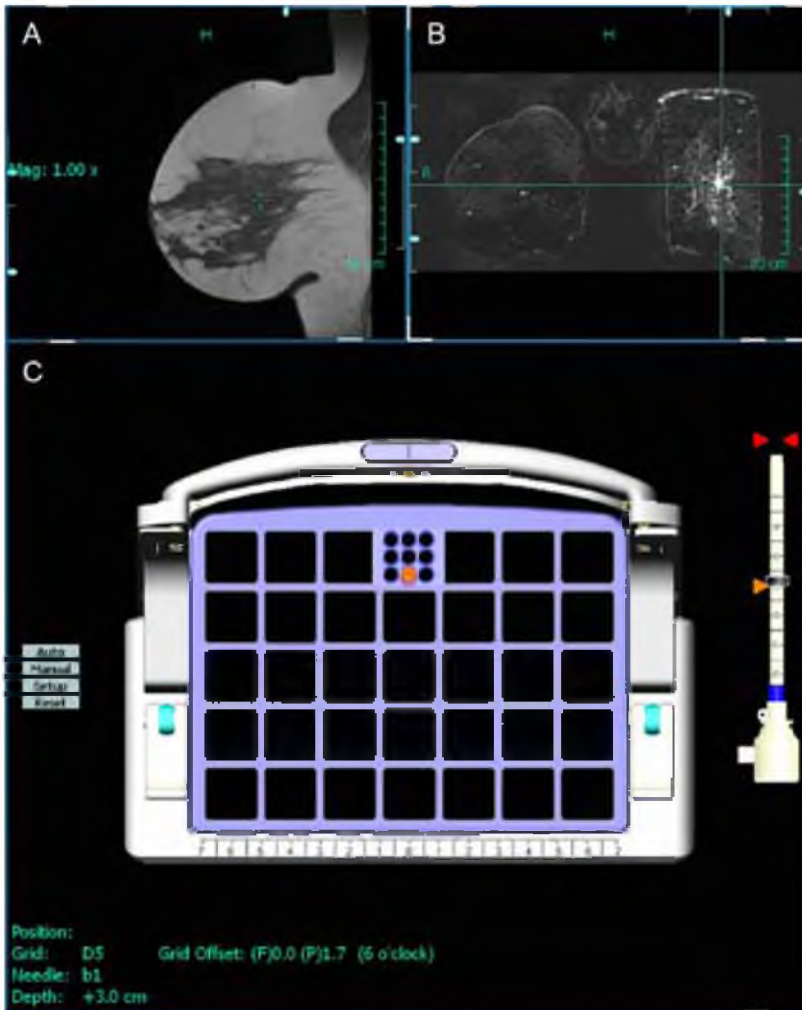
MRI guided breast biopsy of a multifocal ILC in the left breast, after negative mammography and negative second look ultrasound. A computer program (DynaCAD, Invivo, Orlando, USA) is used to accurately position the needle. In A a native sagittal T1 image of the left breast is shown, the needle is currently aimed at the crosshair. In B a subtraction image in the coronal plane of both breasts is shown, which is used to locate the lesion. The lesion is in the center of the crosshair. In C the biopsy grid is shown, it shows where to position the biopsy block (purple block with holes) and in which of the holes to insert the needle (yellow dot) to come closest to the optimal position (red circle). The necessary depth can be read at the bottom of the screen. Using vacuum assisted biopsy, the diagnostic yield is approximately 95%.
